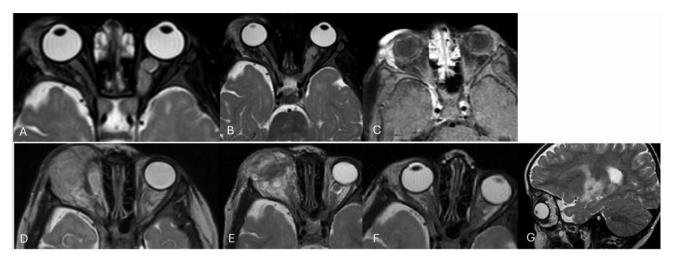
Axial magnetic resonance imaging (MRI) of the patient over time. (A) First image of the mass at the age of one year and five months shows the tumor under the roof of the orbit and predominantly in the lateral area of the cavity. The left-sided optic glioma is shown. (B) Three months later, a similar finding was noted. (C) The tumor appeared unchanged in size but somewhat inhomogeneous three months later. (D) After considerable reduction of the tumor, tumor recurrence appeared just two months later. (E) Four weeks later, shortly before the start of chemotherapy, imaging revealed an inhomogeneous tumor occupying the upper area of the orbit, exiting from the lateral to the medial border. (F) Images of the orbit after two cycles of chemotherapy. The tumor has regressed significantly (two months prior to exenteration; compare with Figure 2A). (G) Sagittal view prior to exenteration.
